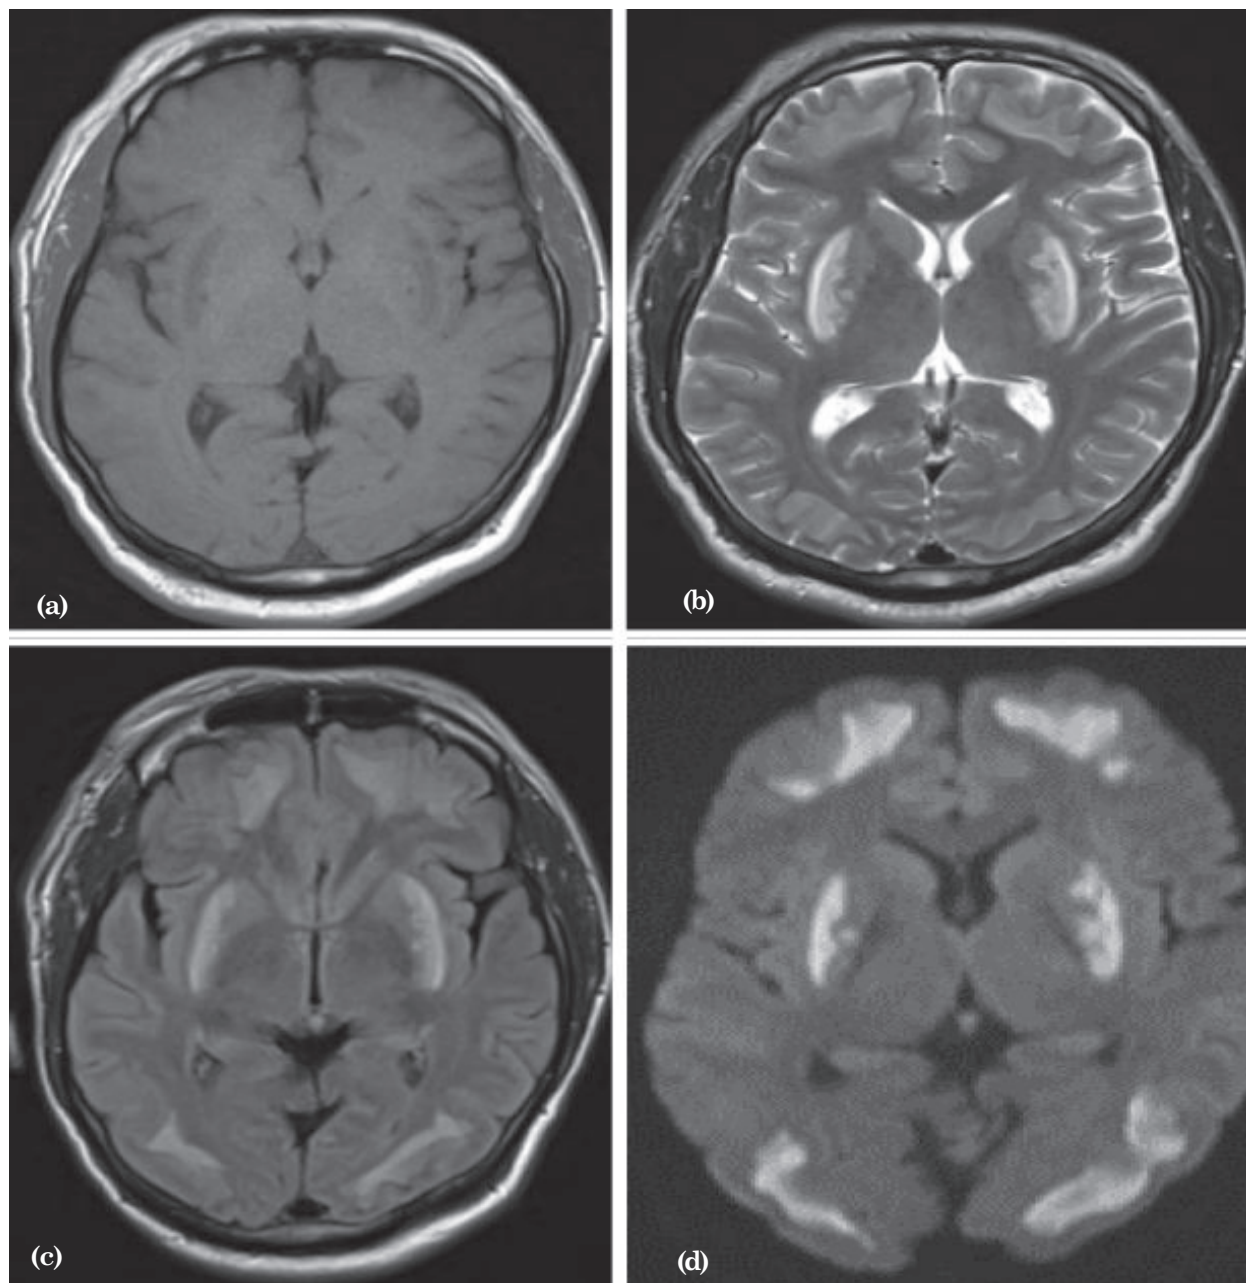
(a, b, c & d) - Axial T1 hypointense, T2 & FLAIR hyper intense, DW restricted image showing putaminal non hemorrhagic necrosis and subcortical change.
